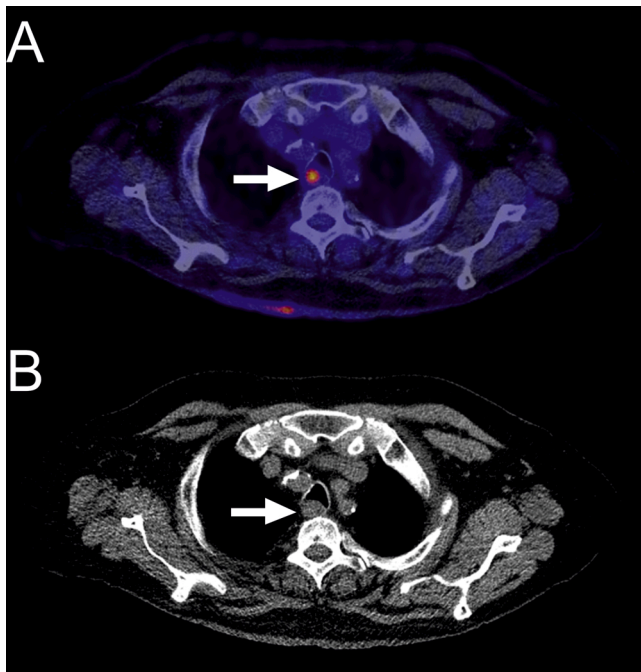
A 71-year-old man with a history of liver transplantation and recent episodes of epilepsy with abnormalities in the left occipital lobe on CT (not shown). Low-dose FDG-PET/CT was performed to evaluate for post-transplant lymphoproliferative disorder. FDG-PET/CT showed pathologic FDG uptake in the left occipital lobe (not shown). Axial fused FDG-PET/CT (A) and low-dose CT (B) are demonstrated. FDG-PET showed focal high FDG uptake in the upper esophagus (A, arrow) with focal wall thickening on low-dose CT (B, arrow), which was interpreted to be most likely of physiological nature in the original report. However, this lesion proved to be esophageal cancer on follow-up. This cognitive error was corrected with an addendum 15 days after authorization of the original report.
